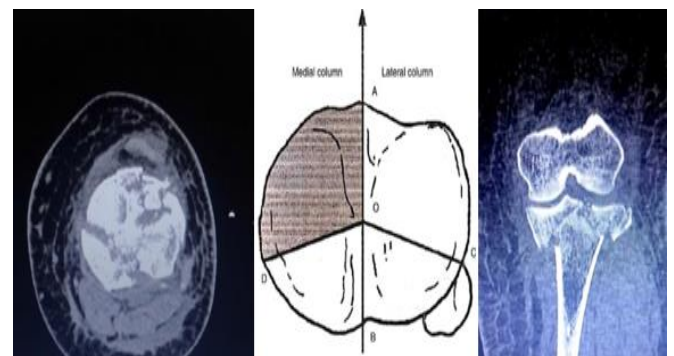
Pre-operative CT Scan Knee (Coronal View; Transverse View)
